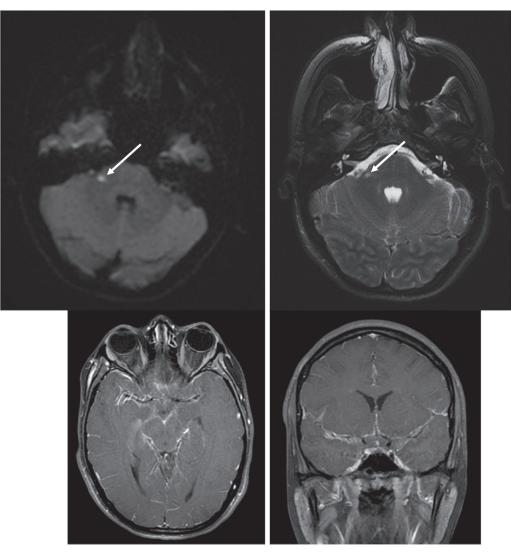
MRI brain with and without contrast. Axial DWI (top left), Axial T2 (top right), Axial T1 post-contrast (bottom left) and Coronal T1 post-contrast (bottom right). Focal lesion with restricted diffusion with T2 signal abnormality in the right brachium pontis (arrow). Diffuse abnormal leptomeningeal enhancement within the basal cisterns and sylvian fissures. Images obtained 45 days prior to patient's fatal outcome.
